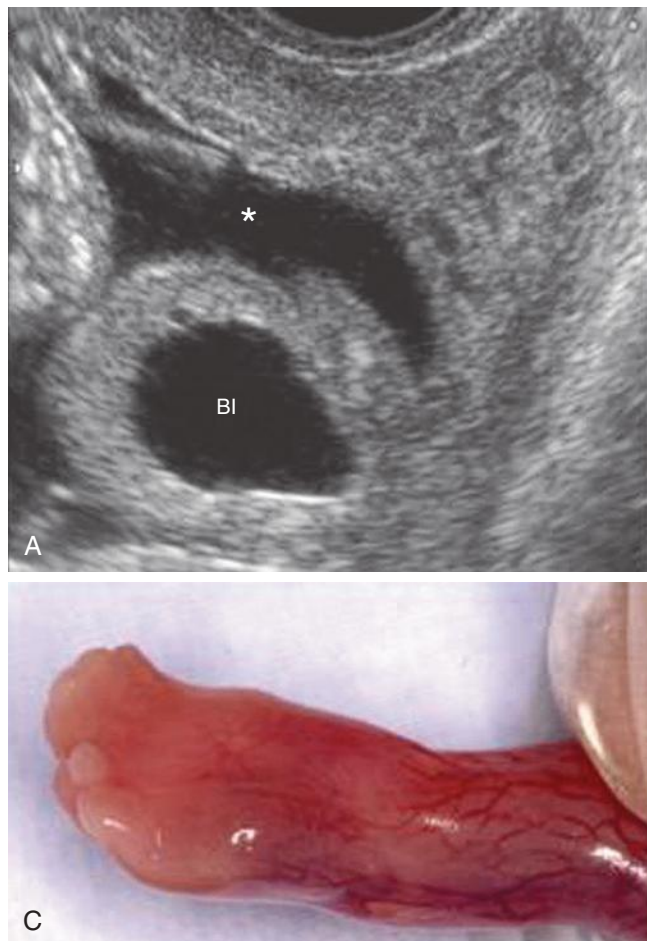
A case of Fraser syndrome diagnosed at 16 weeks' gestation. Megacystis, syndactyly, and oligohydramnios were seen. A, Sonogram demonstrating megacystis and ascites (*asterisk*). B and C, Neonatal images. Note the distention of the abdominal wall and the postmortem feet with syndactyly between the first, second, and third digits. (Courtesy of Fabrice Cuillier, 2005. Available at thefetus.net.)
